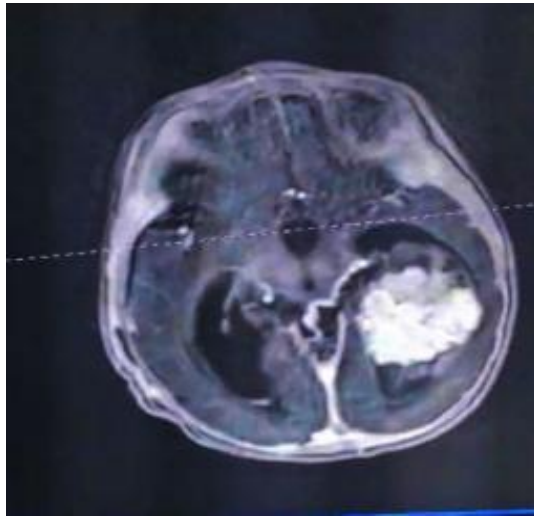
An MRI image showing the lesion on the contrast-enhanced T1-weighted sequence.
